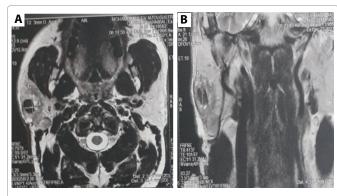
Parotid MRI in axial (A) and coronal (B) sections showing a poorly defined parotid mass extending to the deep lobe in T2 hyposignal with areas of necrosis.
